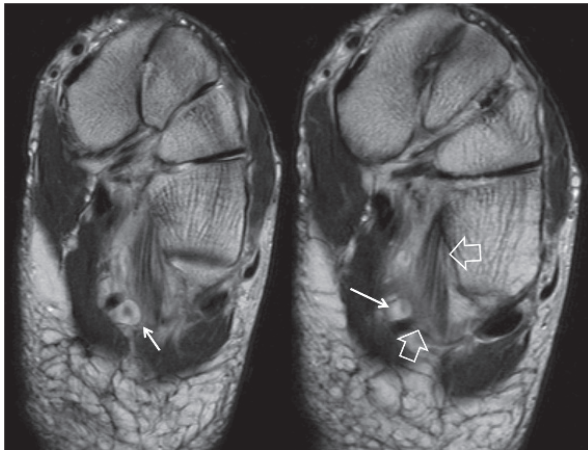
Axial consecutive T2-w MR images showing the varicose lateral plantar vein (arrows) with a small centrally located thrombus and the oedematous quadratus plantae muscle (open arrows).
